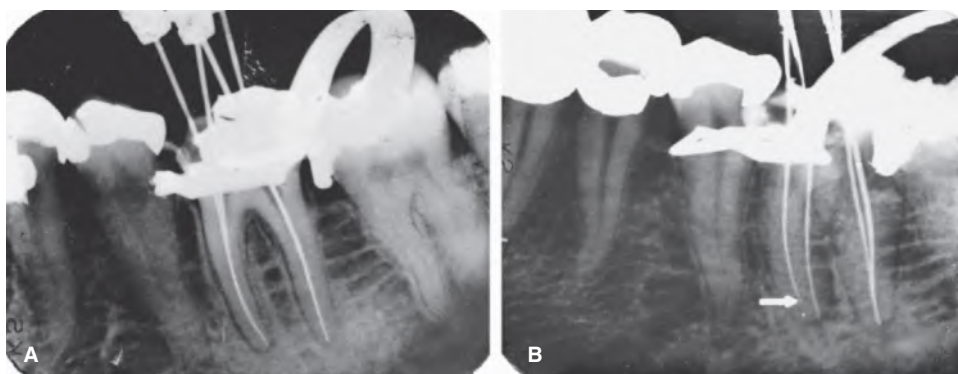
1 Disclosing canals by radiography. A. Right angle horizontal projection reveals four superimposed files. B. Horizontal angulation varied 30° mesially reveals that there are three canals (two files in a broad distal canal). The file is short of working length in the mesiolingual canal (arrow).
